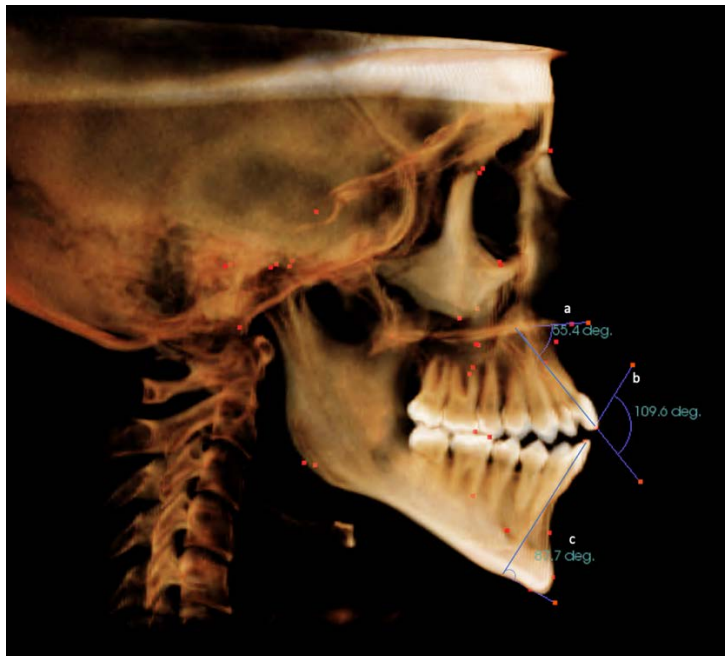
CBCT Measurements. a, U1PPA (upper incisor to palatal plane); b, IIA (interincisal angle); c, IMPA (lower incisors to MP).
